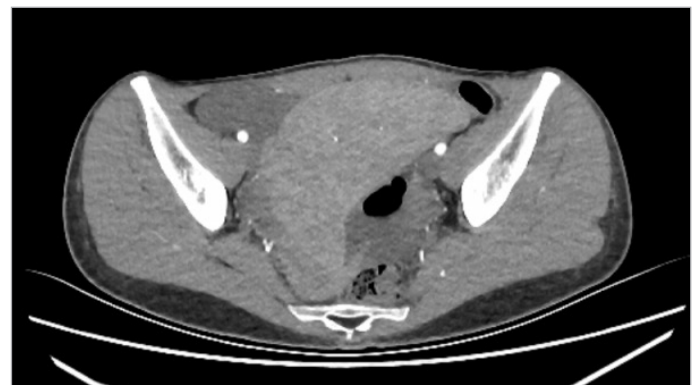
CT: wandering spleen in the pelvis.
